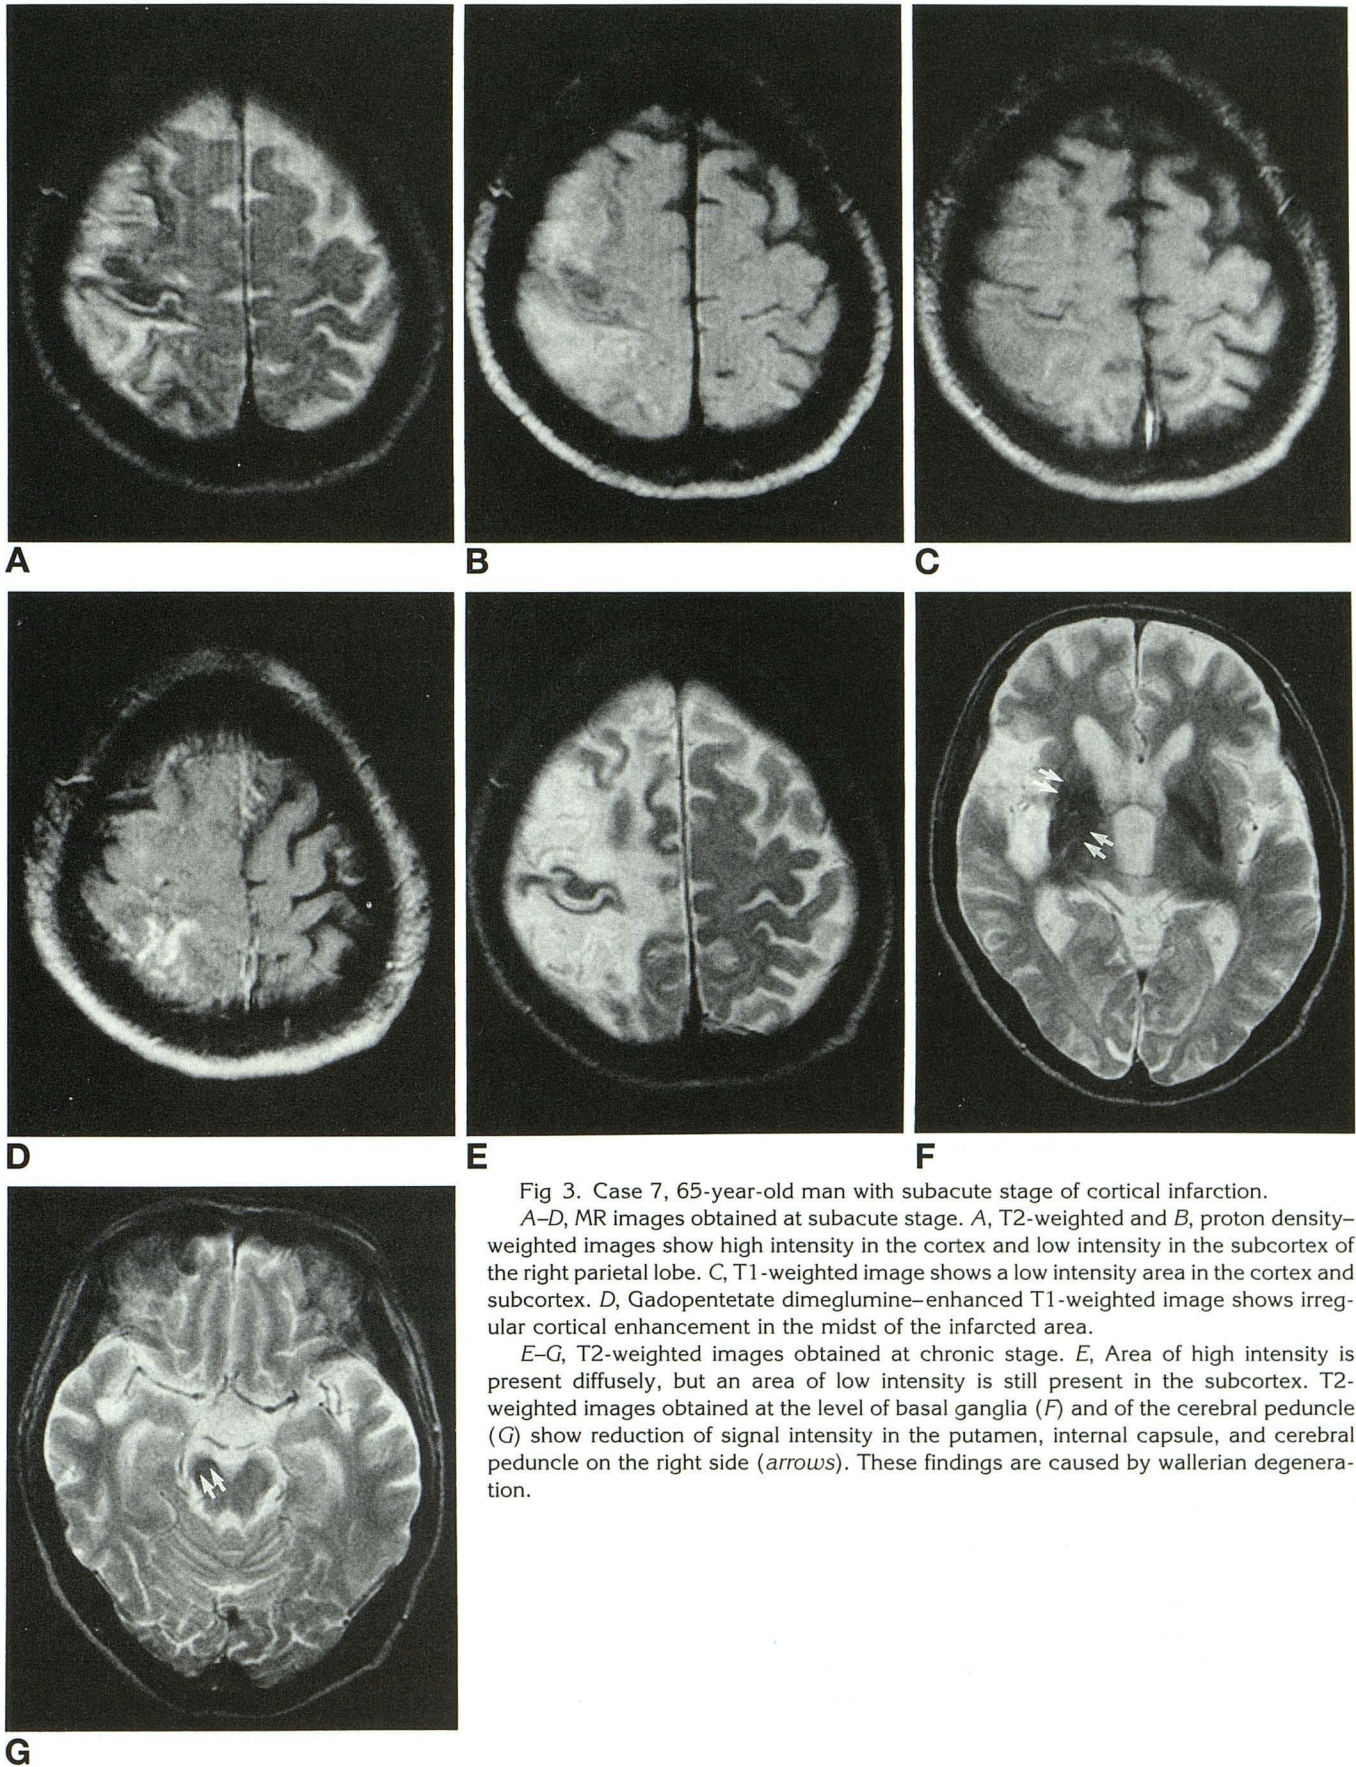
Case 7, 65-year-old man with subacute stage of cortical infarction. A-D, MR images obtained at subacute stage. A, T2-weighted and B, proton density-weighted images show high intensity in the cortex and low intensity in the subcortex of the right parietal lobe. C, T1-weighted image shows a low intensity area in the cortex and subcortex. D, Gadopentetate dimeglumine-enhanced T1-weighted image shows irregular cortical enhancement in the midst of the infarcted area. E-G, T2-weighted images obtained at chronic stage. E, Area of high intensity is present diffusely, but an area of low intensity is still present in the subcortex. T2-weighted images obtained at the level of basal ganglia (F) and of the cerebral peduncle (G) show reduction of signal intensity in the putamen, internal capsule, and cerebral peduncle on the right side (arrows). These findings are caused by wallerian degeneration.
